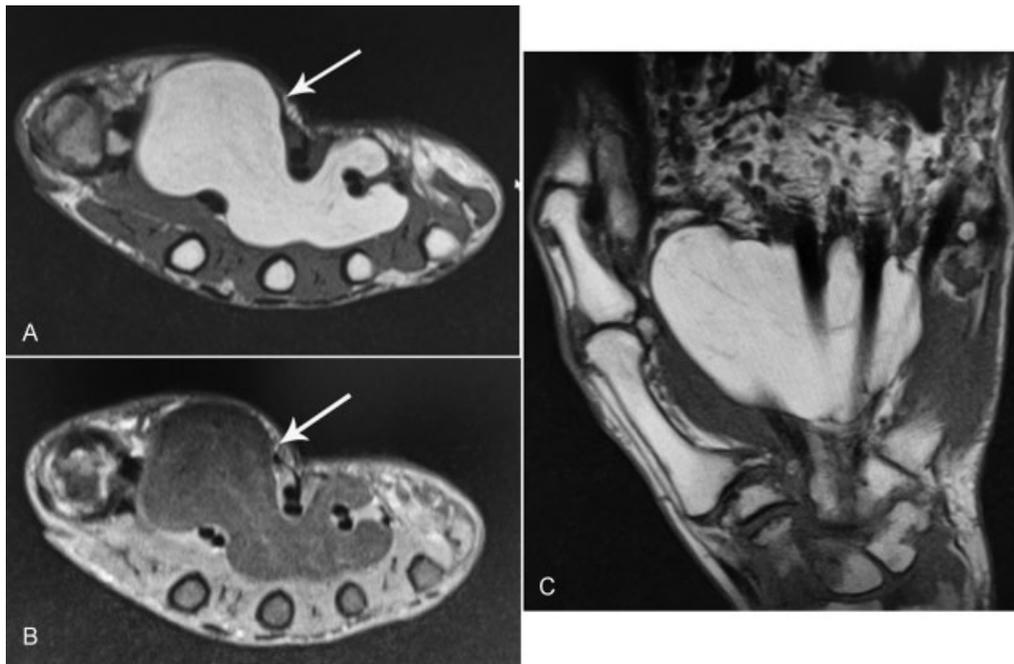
(A) Axial T1-weighted, (B) axial fat-suppressed T2-weighted, and (C) coronal T1-weighted images reveal an intermuscular lipoma at the central region on the palmar side (arrows).
